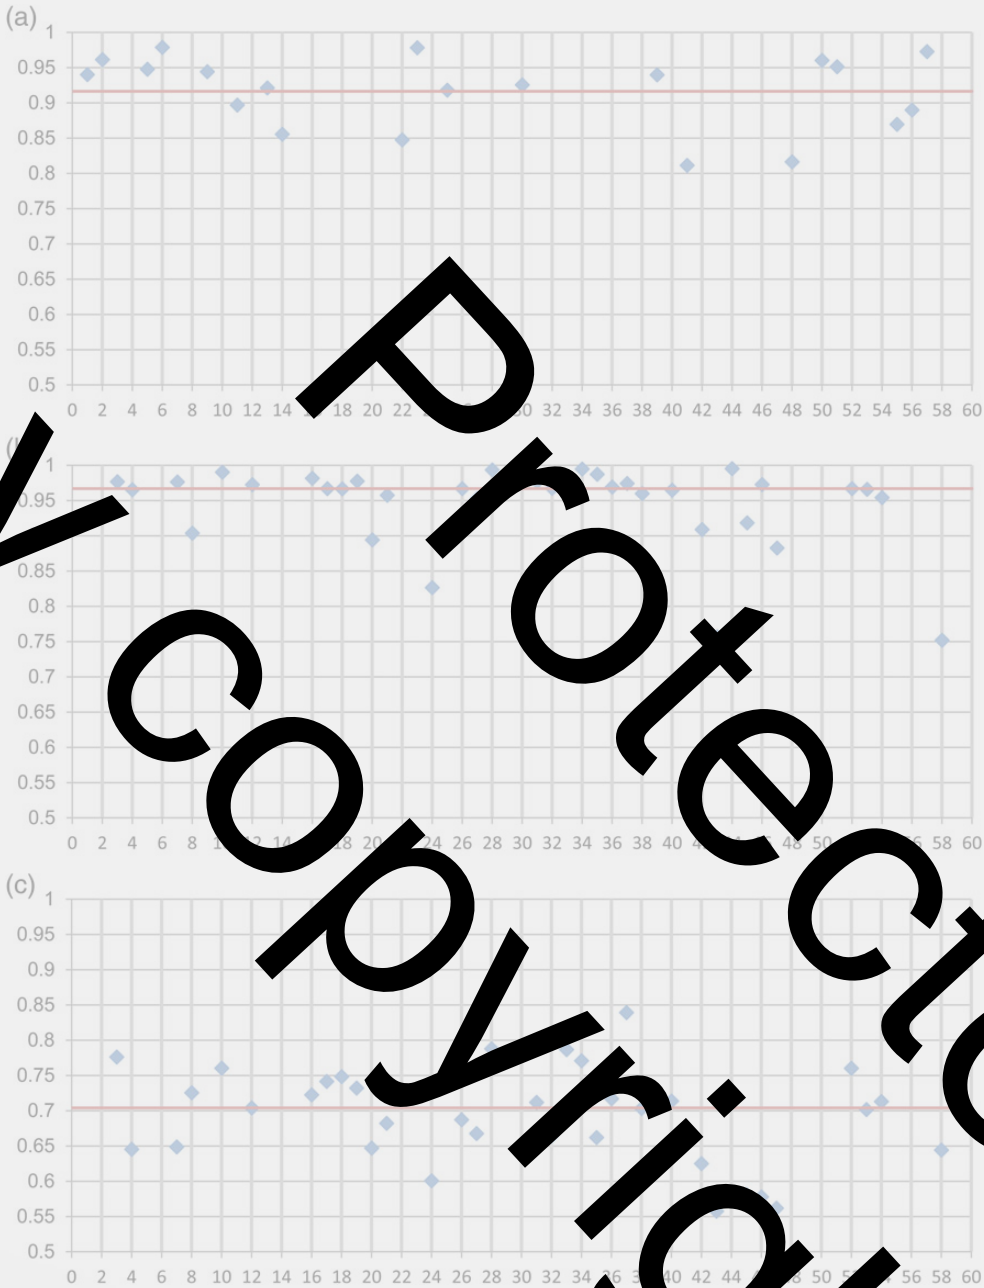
Results of a comparison of the image quality for CT units in Western Switzerland when dealing with the 'Reference' protocol for spheres of 8 mm/10 HU at 2.0 mm slice thickness (a), 5 mm/20 HU at 2.5 mm slice thickness (b) and 5 mm/10 HU at 2.5 mm slice thickness (c). The red line represents the median value.
